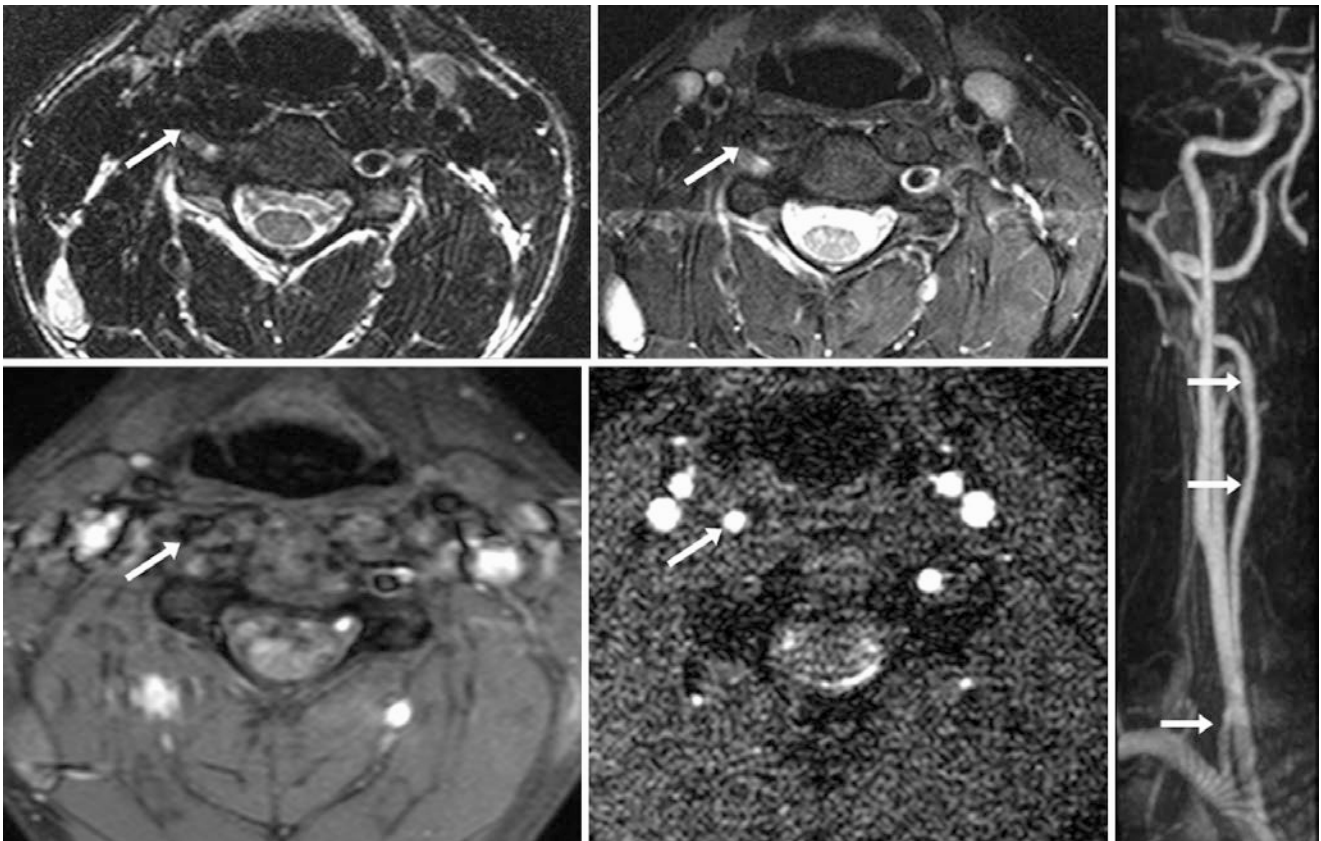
A 17-year-old had a cervical spine fracture that involved the right TF at the C6 level; an MRI was ordered to rule out arterial injury. Initially, the RVA (*arrows*) was not identified prior to or after fat-suppression on T2WI (*top row*) or T1WI (*bottom left*), but it was noted
